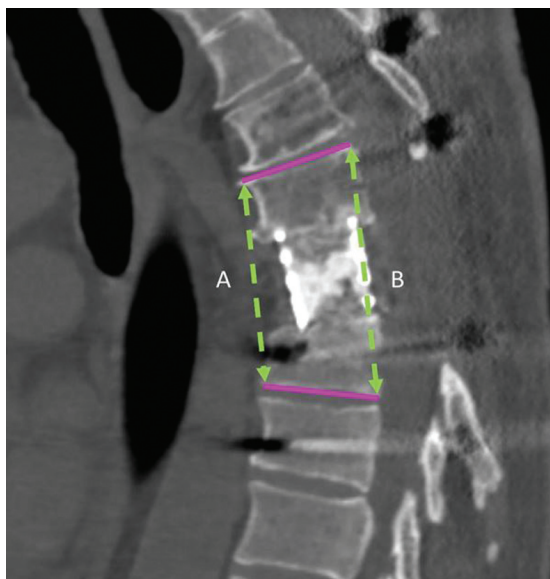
CT scan of the thoracic spine, midsagittal section showing condition after resection of chondrosarcoma of Th7 vertebra: (A) anterior distance of the segment, (B) posterior distance of the segment with vertebral body prosthesis
